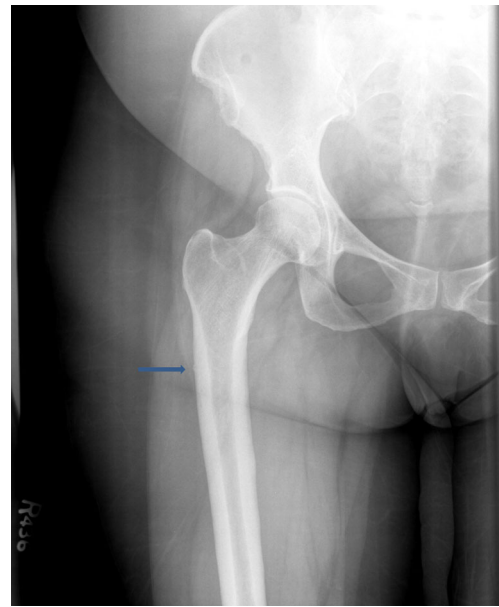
AP radiograph of the contralateral proximal left femur obtained at the time of bone scan also demonstrates characteristic lateral cortical diaphyseal primarily endosteal thickening with typical lateral beaking of the cortex indicative of evolving stress response and potential incipient fracture
